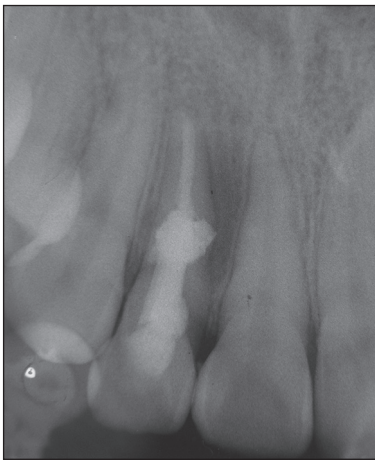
The radiographic appearance of the tooth 3 months after the treatment
